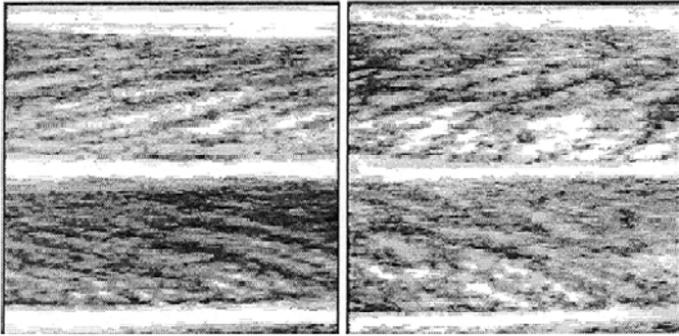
Ultrasonographic image of the tibialis anterior muscle at rest (left image) and in the maximum isometric contraction (right image) states
